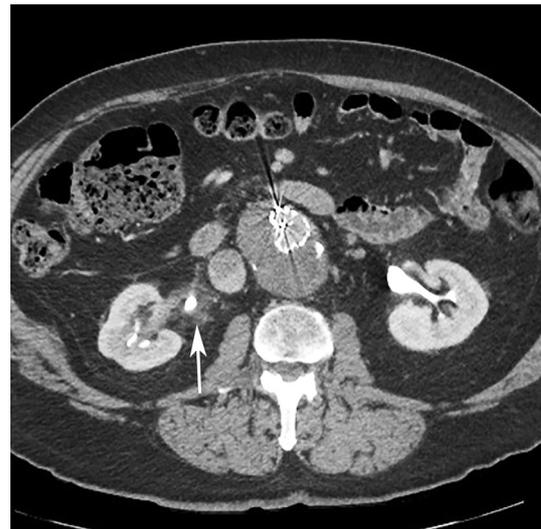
BCG toxicity. An axial split-bolus portal venous and excretory phase contrast-enhanced CT image through the abdomen in a patient who had an upper tract urothelial neoplasm treated with resection and topical BCG shows marked proximal right ureteral wall thickening (arrow). The patient subsequently underwent ureteroscopy with biopsy, which demonstrated that this was an inflammatory granulomatous process
